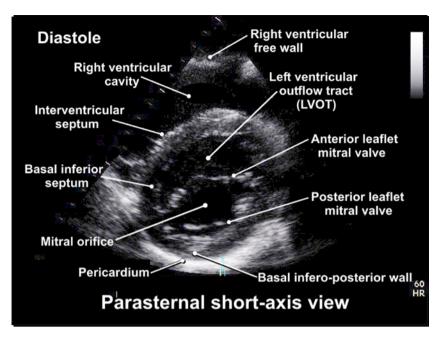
Annotated parasternal short-axis view: mitral valve level (PSAX).
